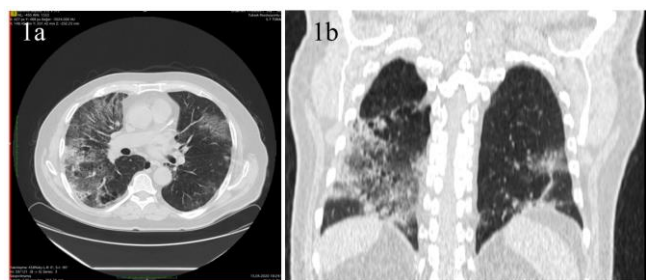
Axial and coronal plane chest CT. In the form of bilateral peripheral consolidated areas, areas with the ground-glass density that affect the large part of both lungs are observed
